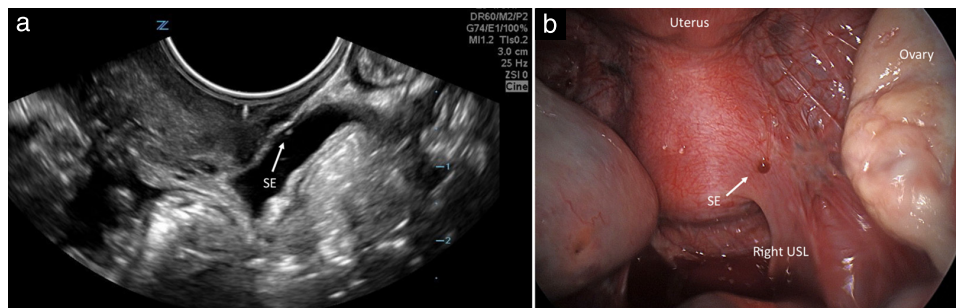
Transvaginal ultrasound (TVS) image (a) and corresponding laparoscopic image (b) showing superficial endometriosis (SE) on the right uterosacral ligament (USL). TVS was performed with infusion of saline in the pouch of Douglas (SonoPODography) to improve visualization. Note that additional SE lesions were visualized on laparoscopy which were not detected on preoperative TVS.
